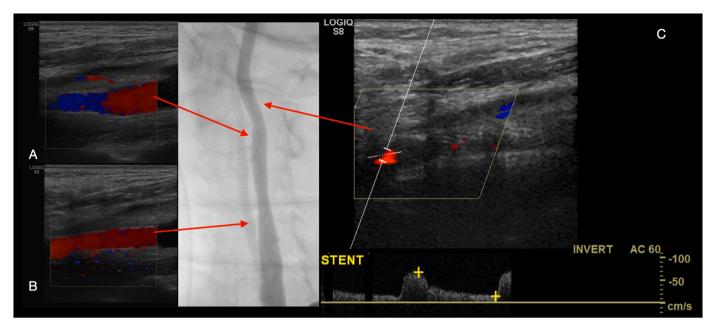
Ultrasound doppler showing stent in distal end (A), medium tract (B), blood flow after stent (C).
